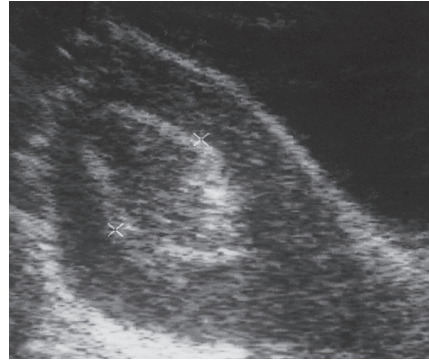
Decidual cast. Transabdominal ultrasound image reveals echogenic material within the endometrium (cursors) with no gestational sac.
